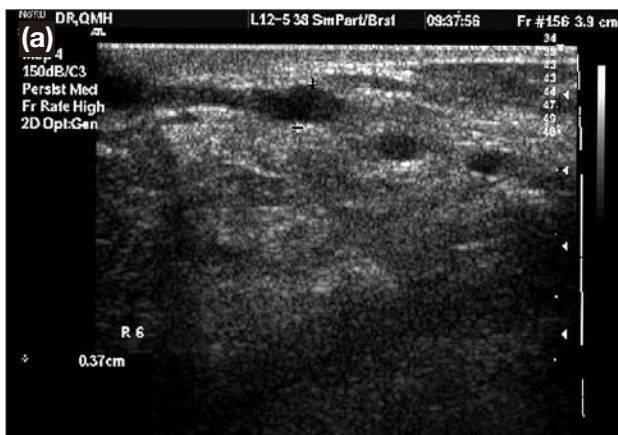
Ultrasound showing (a) dilated ducts up to 3.7 mm at the 6 o'clock position of the right breast; and (b) percutaneous needle puncture (arrow) of the dilated duct under real-time ultrasound guidance.
